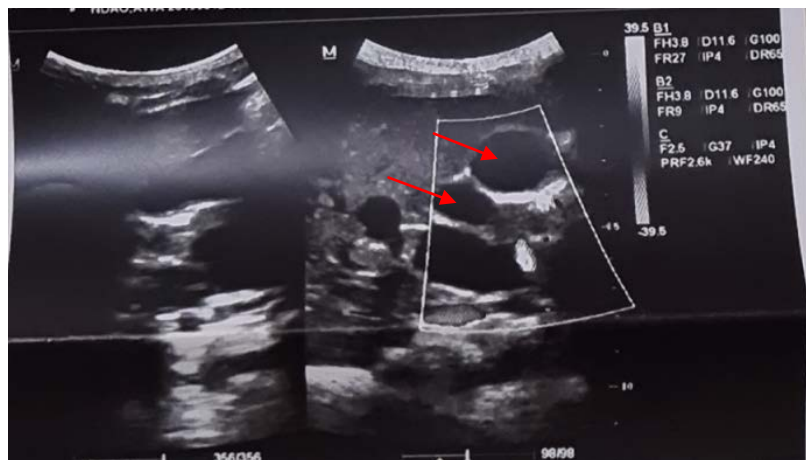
Abdominal ultrasound of patient 2 showing cystic dilation of the main bile duct (red arrows).
